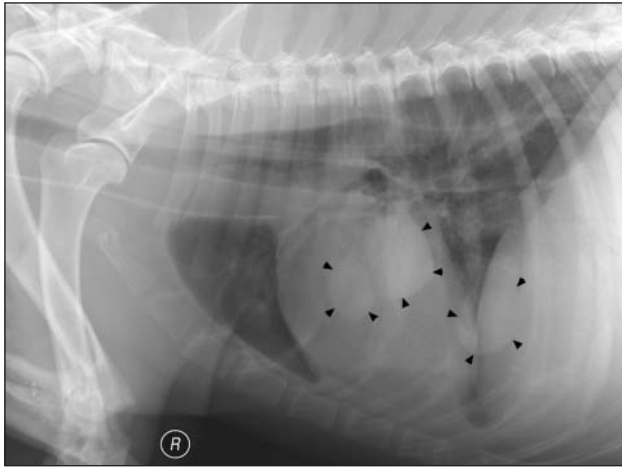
Same radiographic views as in Figure 1. Notice the traumatic pulmonary pseudocysts (arrowheads).
